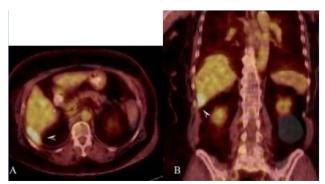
PET-CT Scan: (a) Axial plane (b) Coronal plane.
